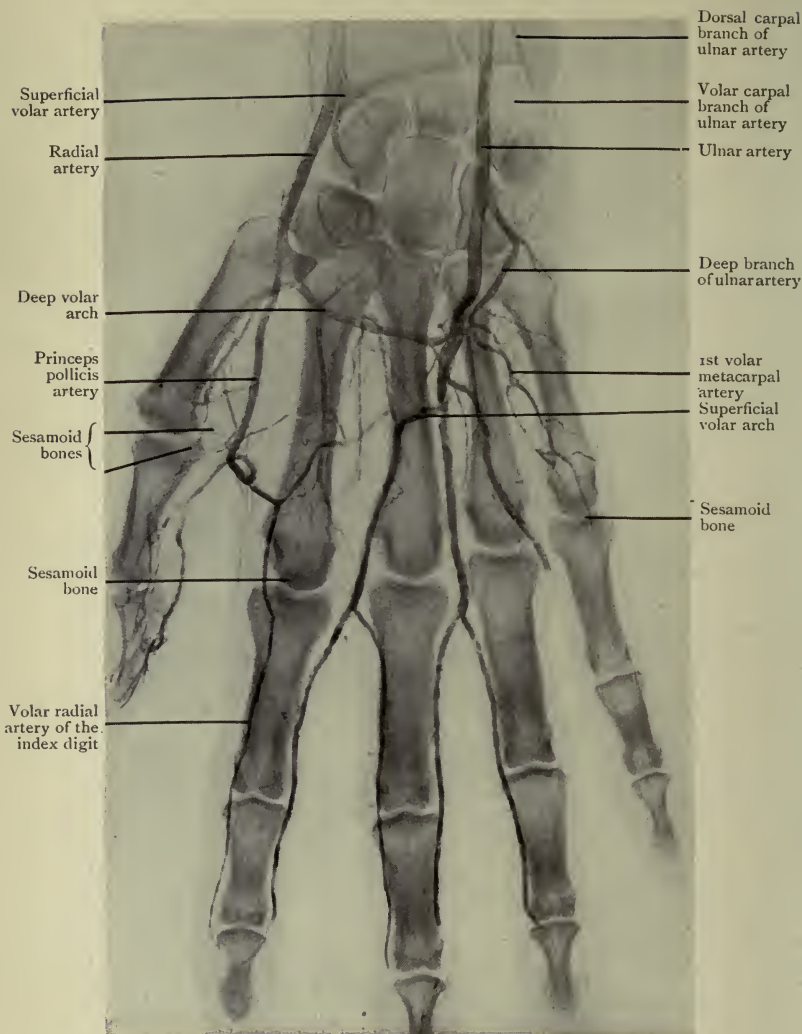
Radiograph of a Hand in which the Arteries were injected.
